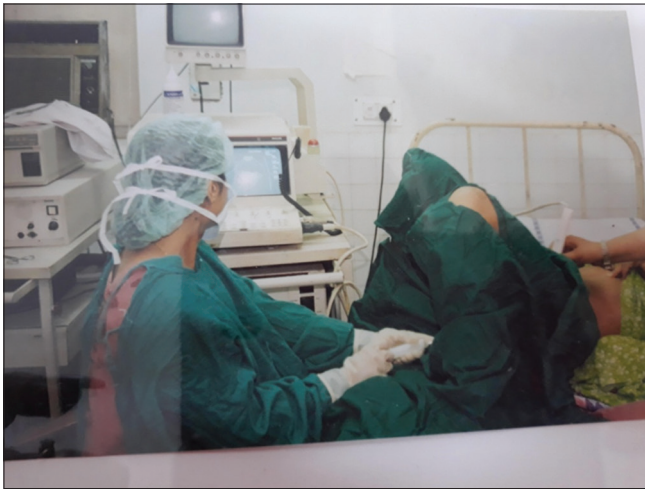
Ultrasound guided tissue obtained by transcervical route (infant feeding tube)
